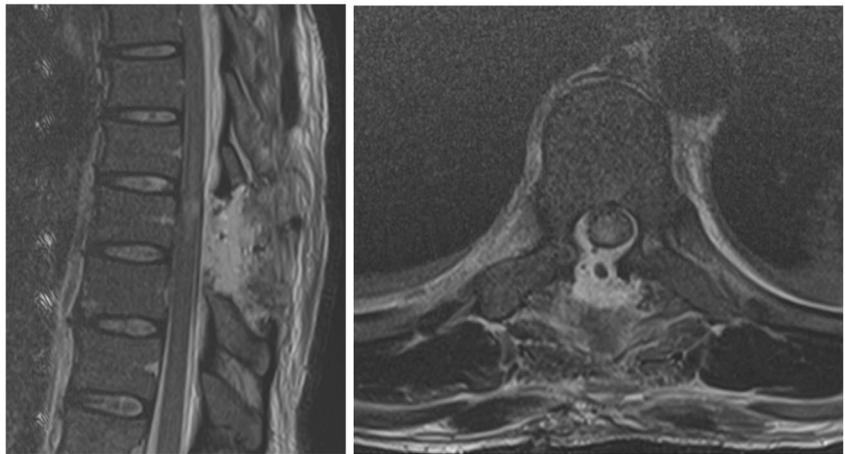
Post-operative MR T2-weighted images in sagittal (*left*) and axial (*right*) plans revealing the intramedullary cord signal change without associated hematoma
